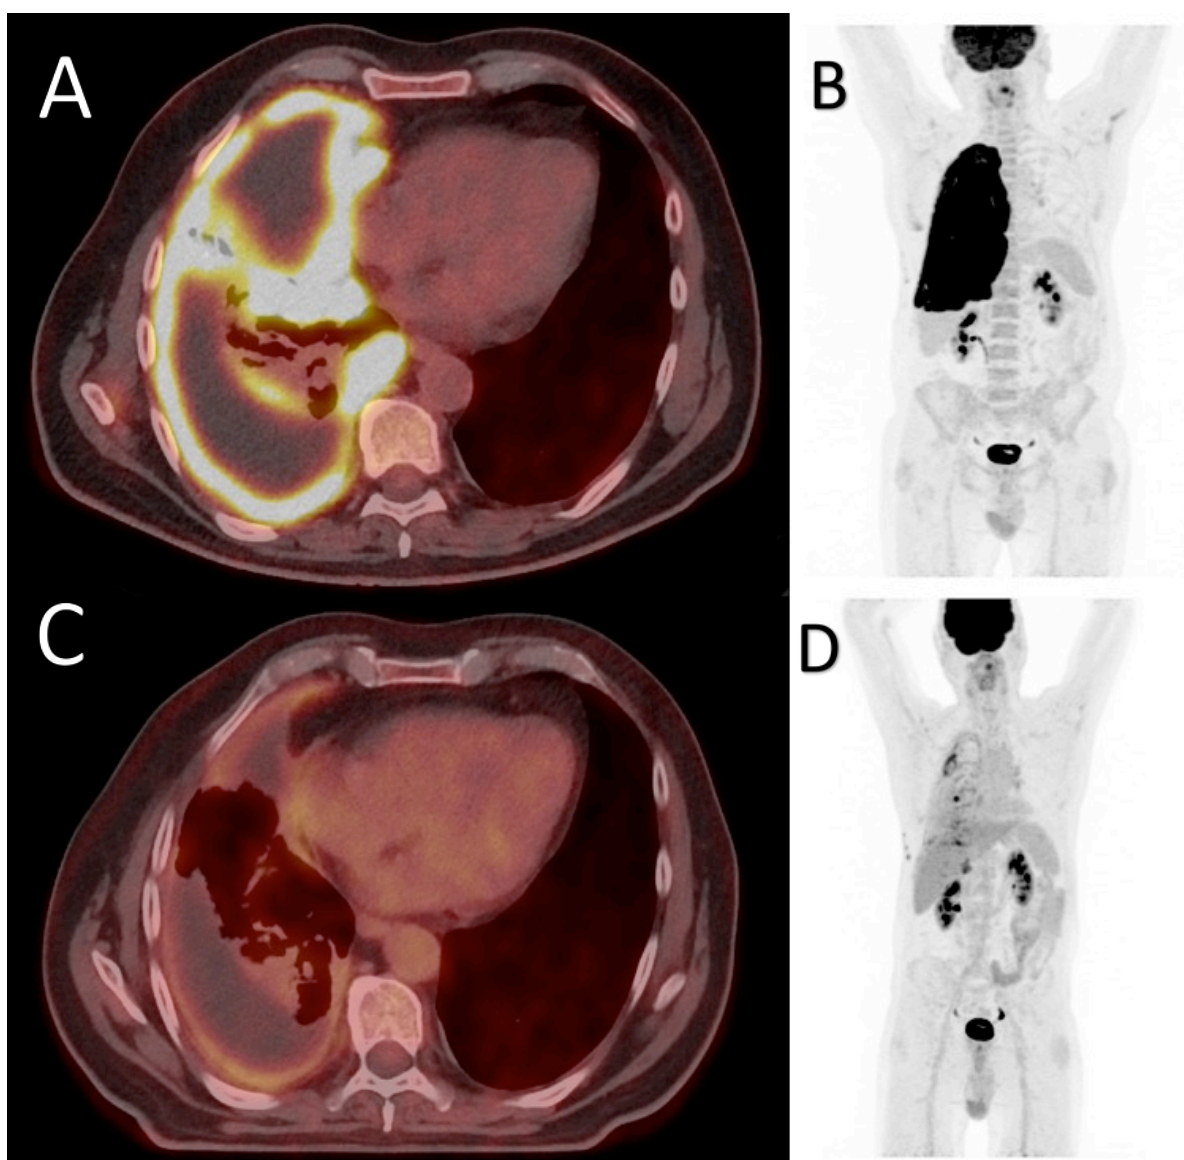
Pre and post-3 cycles of treatment PET-CT scans for RUH405 in the randomised arm of the trial. Images A and B showing high uptake on PET scan with the entire pleura displaying avid FDG uptake (bright yellow area on image A and black area on the right chest on image B). Images C and D show a significant reduction in the FDG uptake after 3 cycles of treatment.
